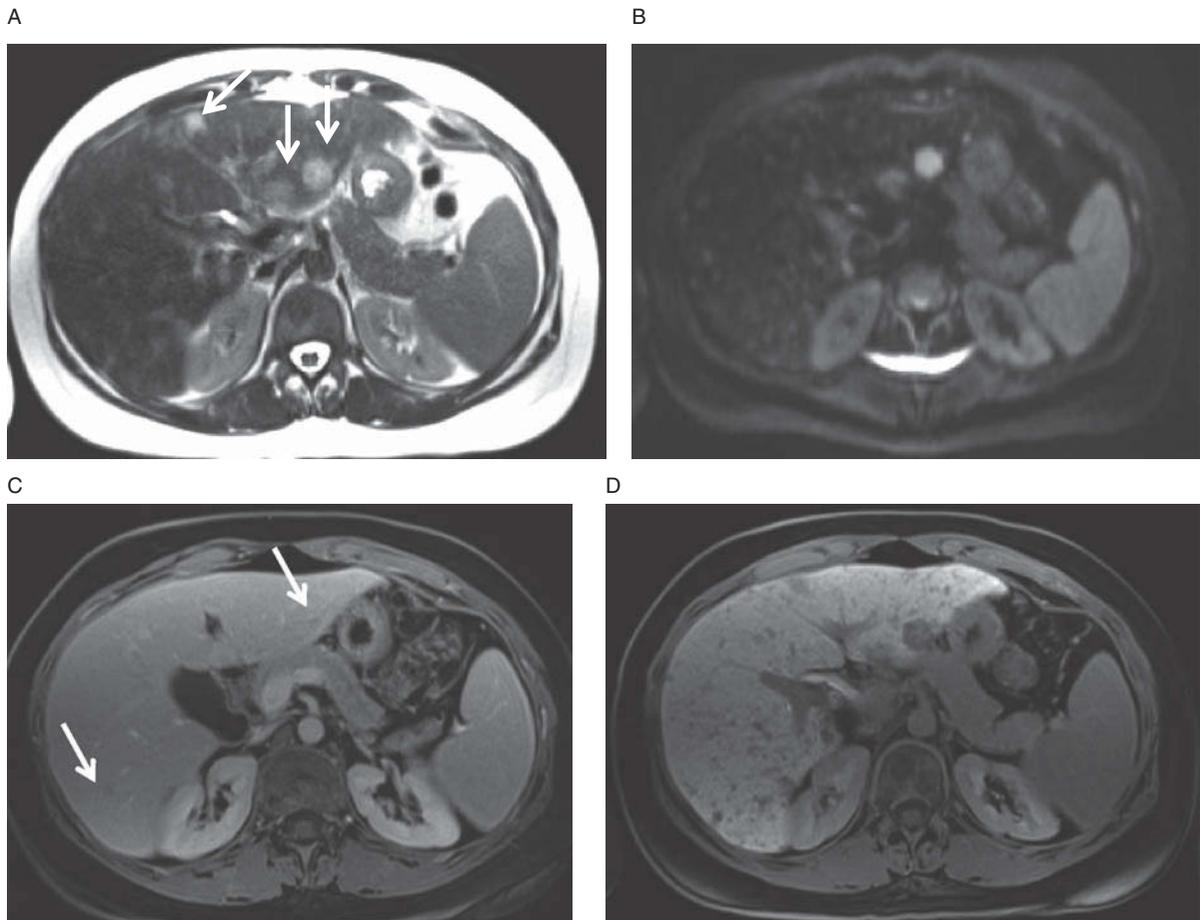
Hepatic metastases with gadoxetate disodium. Multiple, moderately T2-bright lesions are seen throughout the liver (arrows) (A) which demonstrate restricted diffusion (B). These lesions are also seen on portal-venous phase (C). Note however, that on the delayed image (D) we see numerous small, dark lesions with washout of contrast T1-weighted, fat-saturated representing metastatic disease, much more prominent than on the portal-venous phase.
